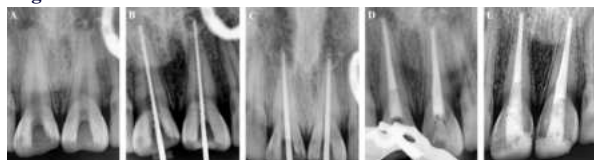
Intraoral periapical radiographs. A) Preoperative, B) working Length, C) Master Cone fit check D) GIC plug placement after obturation, E) 1.5 year follow up radiograph.
